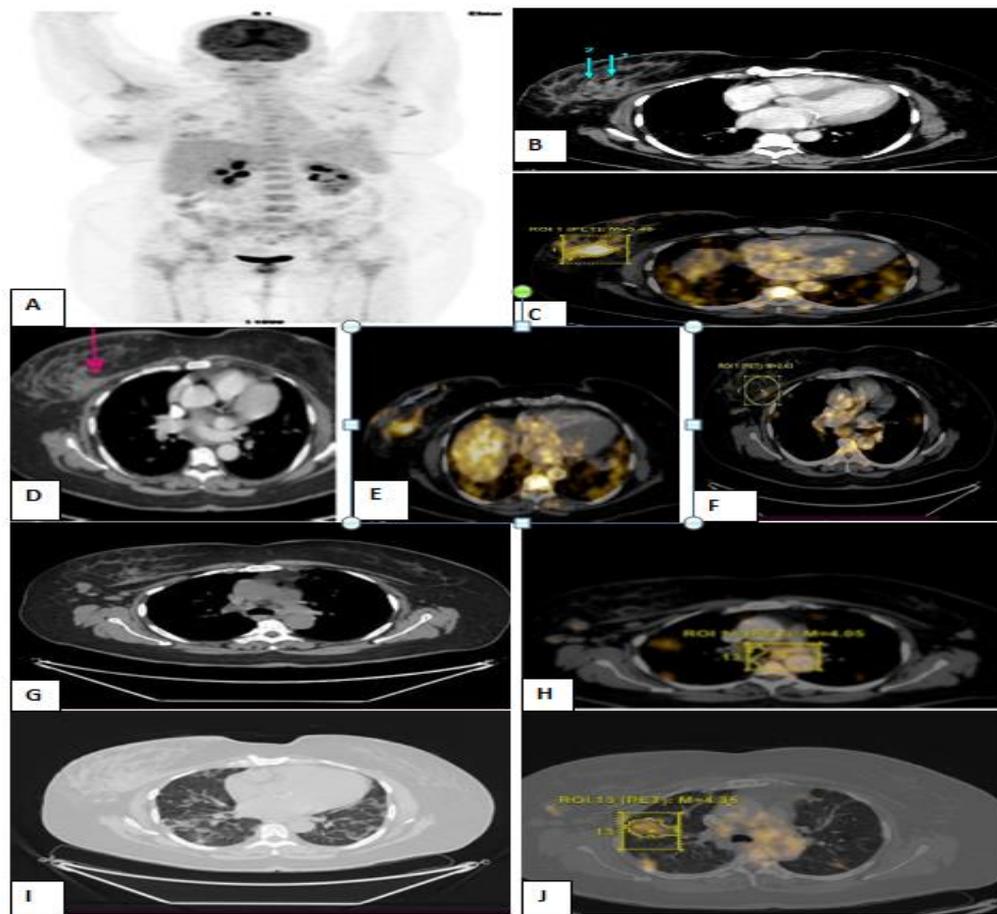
A 64 years old female patient present with right breast cancer (IDC). A: whole –body PET MIP picture active right breast cancer. B&C: axial CT scan a and fused PET /CT scan of the chest revealed an ill-defined hyper metabolic heterogeneous soft tissue mass is noted at lower outer quadrant of right breast with irregular border and speculated margins(green arrows) measured about 28x24mm and uptake achieving SUVmax up to 5.4. D,E&F: the breast mass infiltrating the most lower of right lateral chest wall muscle(pink arrow) achieving SUV max 2.43. G&H: axial CT scan axial fused PET /CT scan of the chest revealed multiple enlarged metabolically active mediastinal lymph nodes largest one measuring about 23x18mm and achieving SUV max up to 4.05,not appeared in CT alone. I&J: axial CT scan axial fused PET /CT scan of the chest show reticular bands on CT image which displayed peripheral irregular interlobular nodular septal thickening uptake achieving SUV max up to 5.02. The patient was stage IIIB (T4 N2 M0) by CT and upstaged into stage IV (T4 N2 M1) by PET CT.
